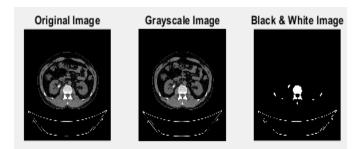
Loading and preprocessing of CT image.
